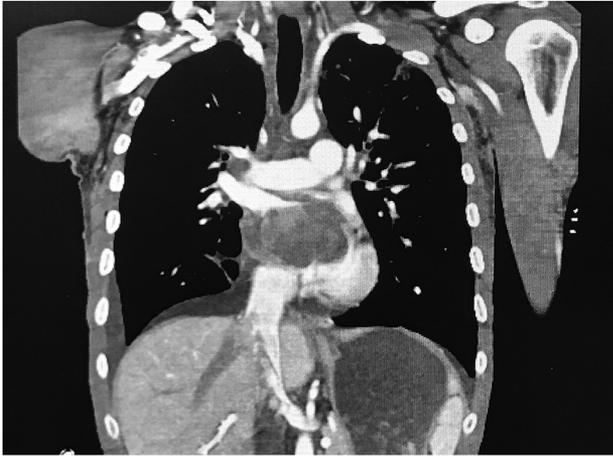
CT angiography of the chest, coronal view, the tumor can be seen in the left atrium invading the right lung.
